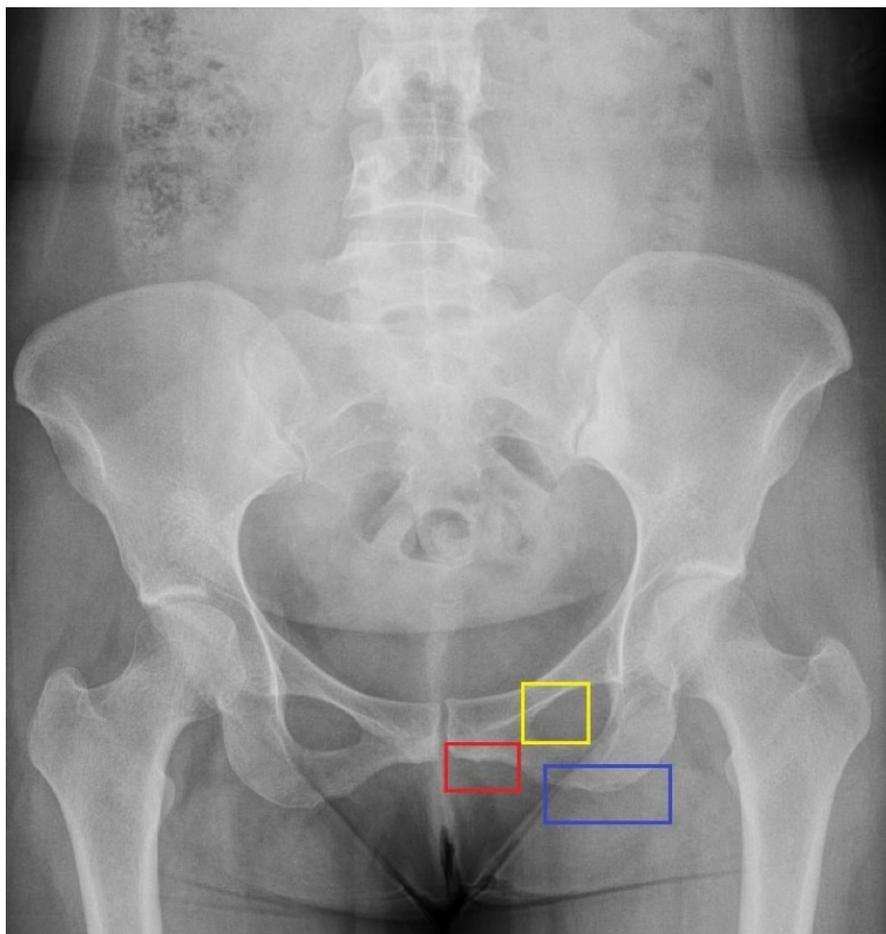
Pelvic radiograph of a 35-year-old female patient with axial spondyloarthritis, showing three distinct zones delineated with colored outlines along the anatomical margins: Zone I (ZI, yellow) corresponds to the iliopubic ramus; Zone II (ZII, red) denotes the pubic symphysis; and Zone III (ZIII, blue) represents the ischiopubic ramus.
